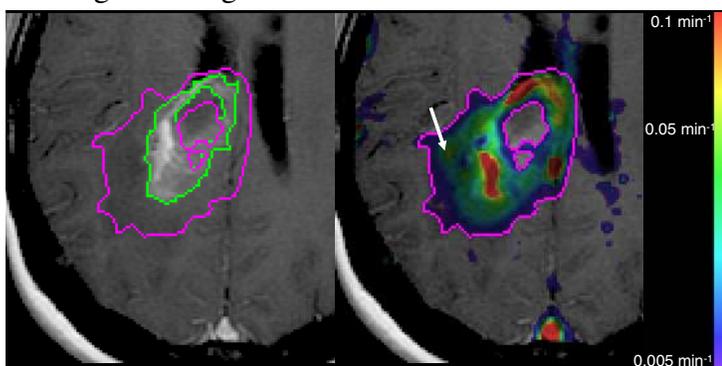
Post-contrast T1-weighted image (left) and the color-coded permeability map (right) overlaid on the post-contrast T1-weighted image. Green contours enclose the contrast-enhanced rim seen on the T1-weighted images while dark pink contours enclose the volume that has the vascular permeability to Gd-DTPA greater than 0.005 per minute.
